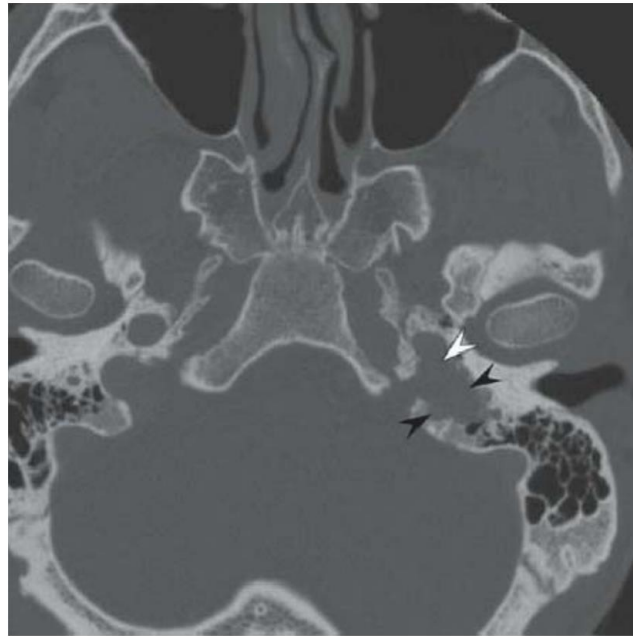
Glomus jugulare. Axial CT showing classic bony erosion of the left jugular fossa and caroticojugular spine (*black arrowheads*). The tumor abuts the posterior aspect of the vertical petrous carotid artery (*white arrowhead*).
